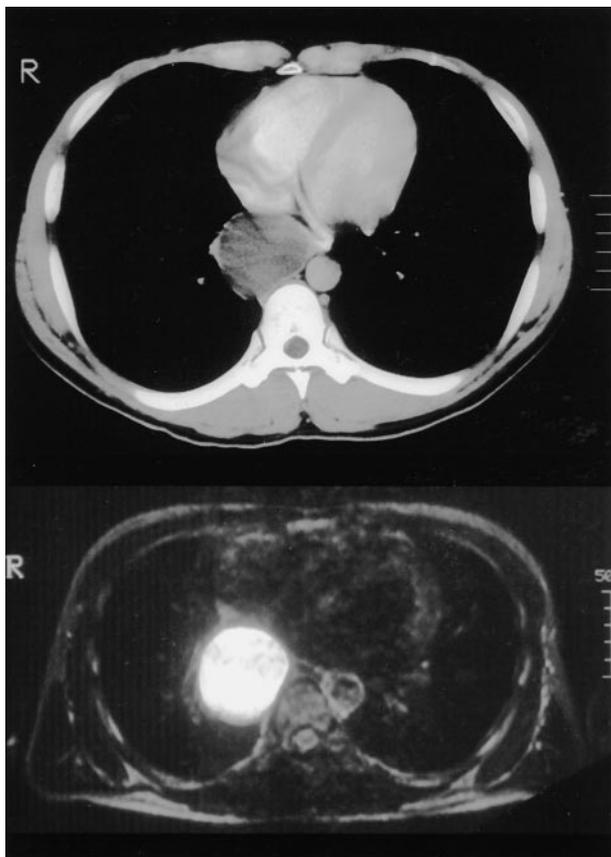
Chest CT scan (*top*) and MRI (*bottom*) of the subcarinal bronchogenic cyst.
